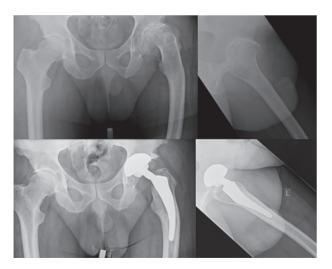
Fig 2a, 2b, Pre-operative anteroposterior (a) and lateral (b), pelvic radiograph of a 48-year-old man with post-traumatic proximal femoral deformity and end stage coxarthrosis. Fig 2c, 2d postoperative anteroposterior (c) and lateral (d) at four years showing placement of the custom-made femoral component.
